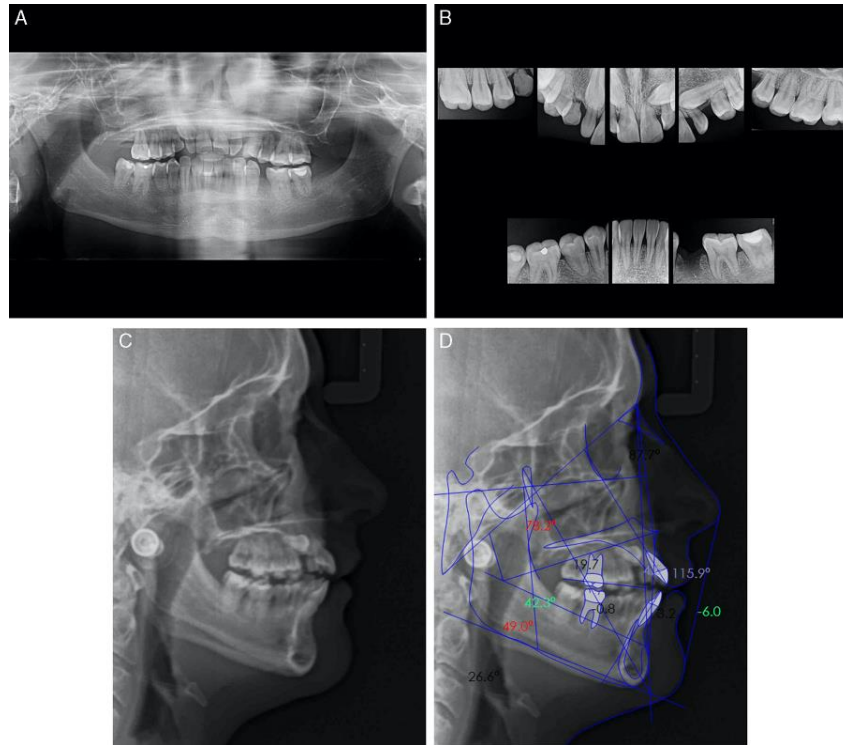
Diagnostic records (A) panoramic X-ray, (B) periapical radiographs, (C) cephalometric radiography, (D) ricketts cephalometric tracing.
